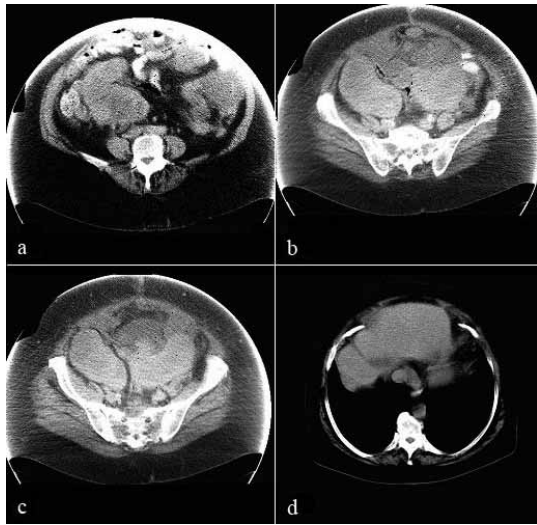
Computed tomography (CT) findings one month after surgery a) tumors in the abdomen b) tumors extruded between small intestines toward the bottom of the pelvis c) tumors in greater pelvis d) metastasis in the liver.
